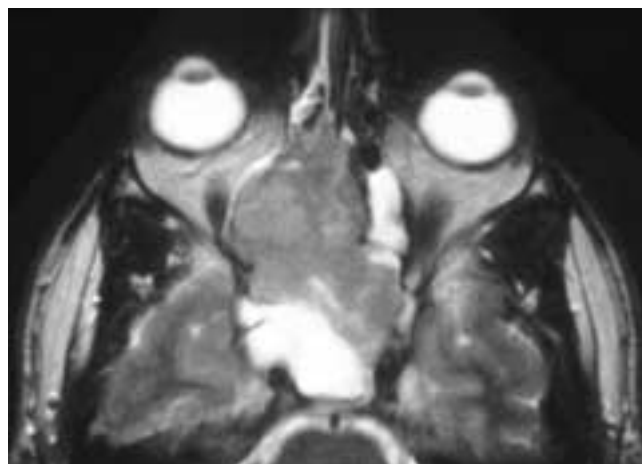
Axial T2-weighted MR image shows a destructive mass in the nasal fossae and both ethmoid complexes. The tumor has extended into the right orbit and the sphenoid sinus, which contains obstructed secretions. Both cavernous sinuses are also invaded. This patient had an olfactory carcinoma.
